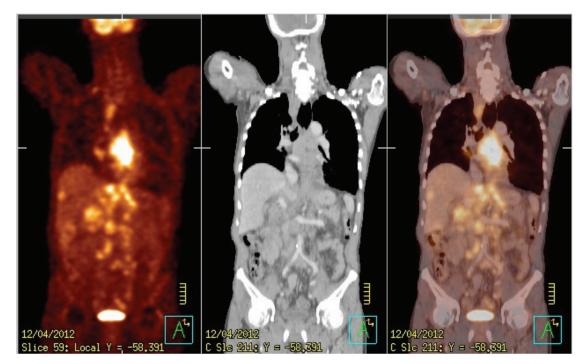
PET image, CT image and PET image fusion with CT image
